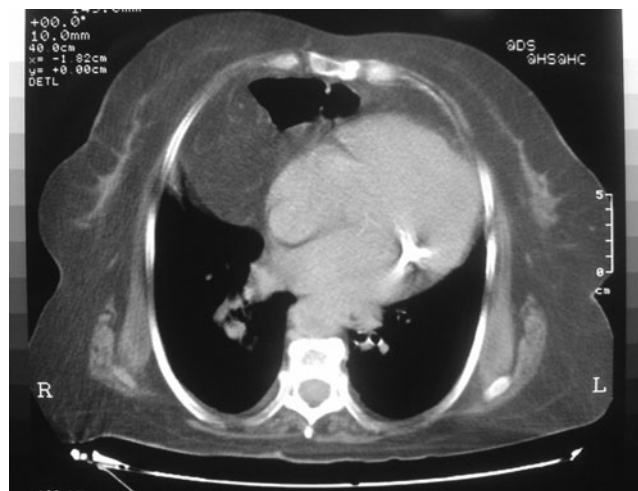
Herniation of abdominal contents (colon gas) into the thorax as visualized by thorax computed tomography
